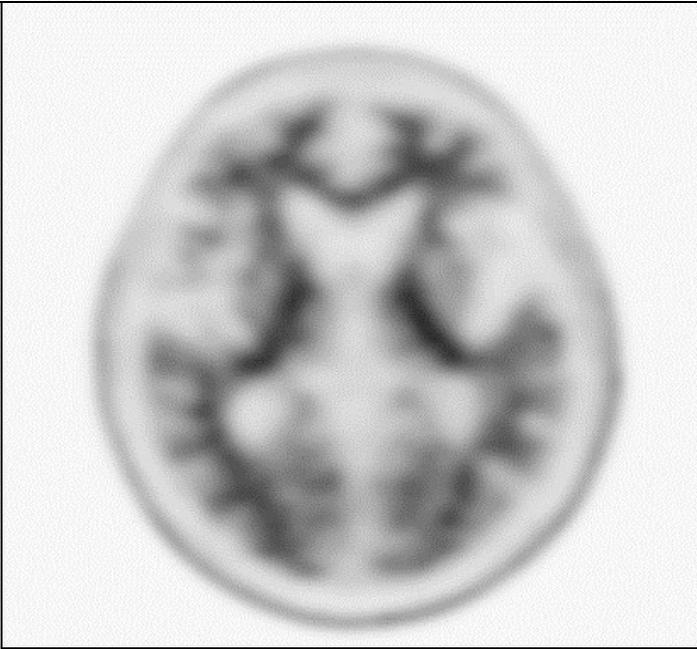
Negative Amyloid Scan. This PET/CT scan is negative for significant amyloid in the brain. The radiopharmaceutical (black) accumulates only in the white matter in a pattern that can be described as “mountain ridge”. This scan is not consistent with Alzheimer’s disease.
